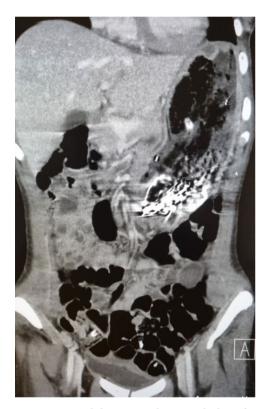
CT abdomen single coronal plane for same patient.
